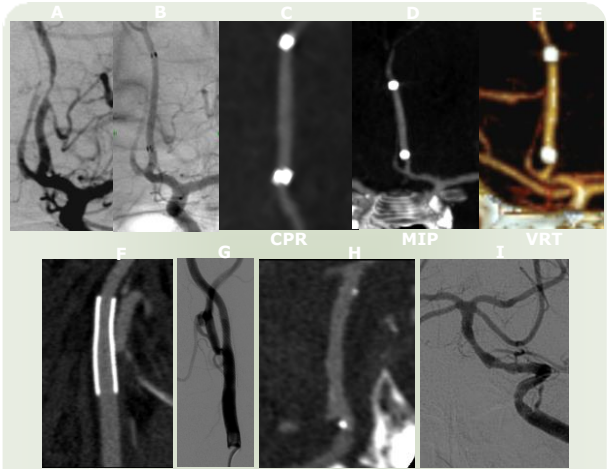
Case 1 (A-E) 59 year-old male with right ACA territory stroke caused by right ACA occlusion. The left ACA A2 segment was severely stenosed. This solitary left ACA A2 high-grade stenosis was treated with balloon angioplasty and stent placement. After 1 year of close invasive imaging the patient was followed with CT angiography. CT angiography showed no restenosis.
